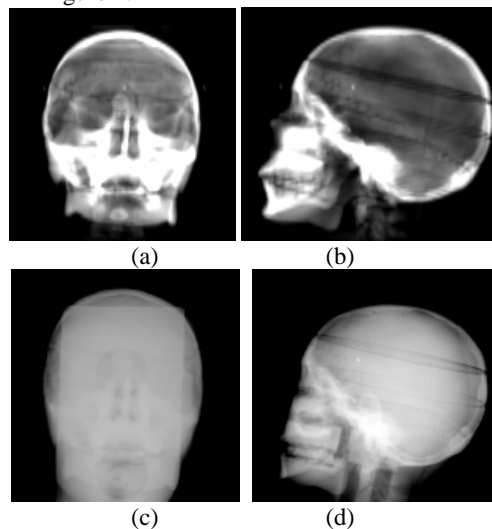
The fixed images and moving images: (a) fixed DRR image at 0°; (b) fixed DRR image at 90°; (c) moving x-ray image at 0°; (d) moving x-ray image at 90°
